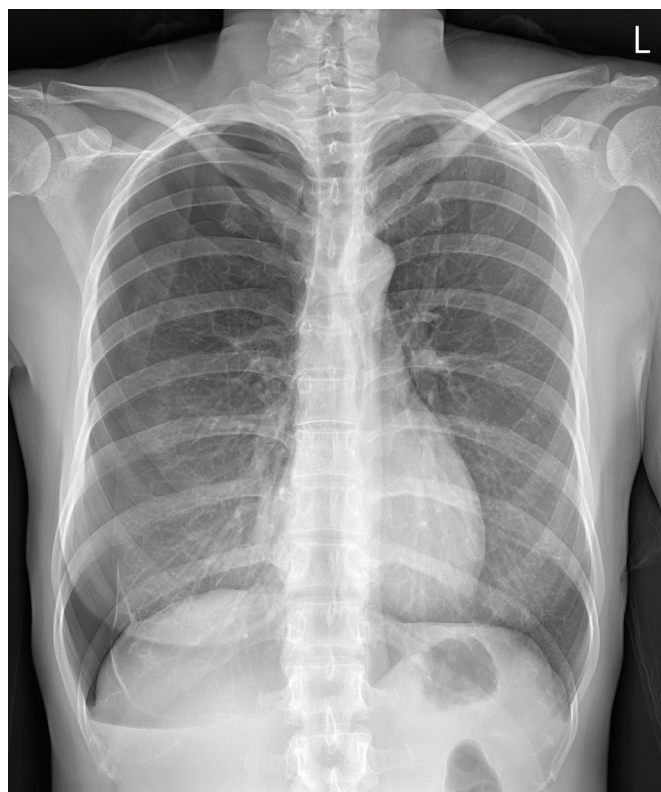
Chest X-ray revealed right pneumothorax and calcified pleura in right lower lung.
